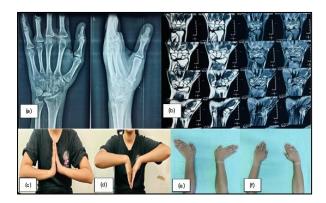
(a) Preop X-ray and (b) MRI film of 18 years/ f with stage IIIb Kienböck's disease left side. Pre-operatively, the patient demonstrated a range of motion at the wrist joint on the affected left side, with the following measurements (c) dorsiflexion of 45°, (d) palmar flexion of 35°, (e) ulnar deviation of 20° and (f) radial deviation of 5°.
